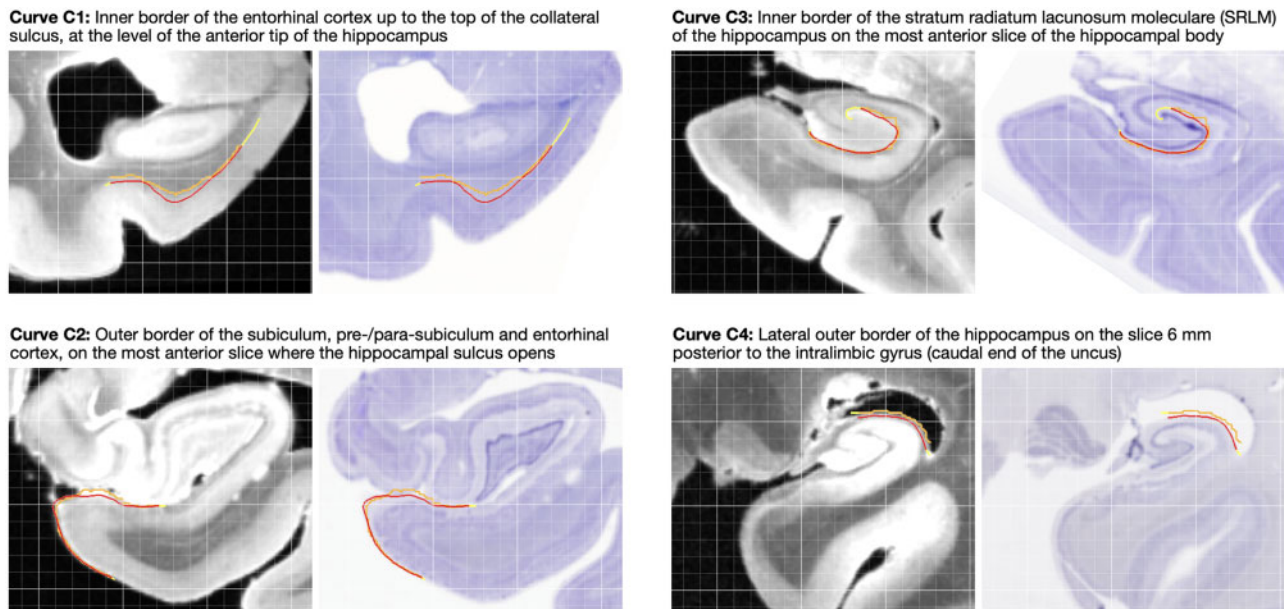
Examples of curve-based evaluation of registration between 9.4 T MRI and reconstructed Nissl slides. Four anatomical curves (C1–C4) were traced independently in Nissl space (orange) and MRI space (red). To account for mismatch in the direction orthogonal to the Nissl slice plane, curves in MRI were traced on consecutive MRI slices (typically nine), and the red curve in the figure is the intersection of the resulting surface with the Nissl slice plane. After registration, the symmetric RMSD between the registered curves was measured, with regions where curves overhang (yellow portions) excluded. The four examples shown here correspond to median registration performance for each curve.
